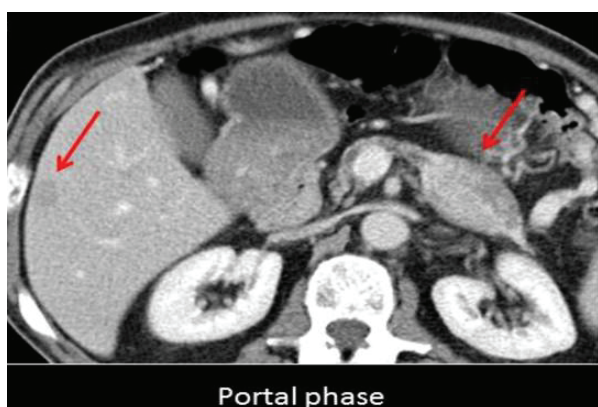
CT image in the portal phase-pancreatic neuroendocrine tumor with liver metastases
